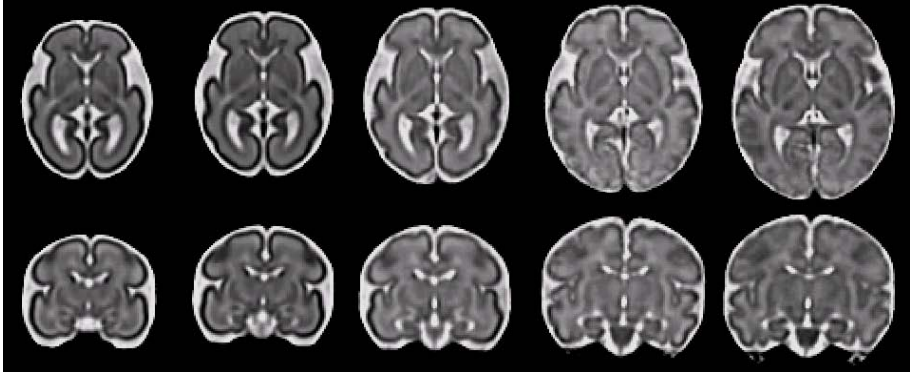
Five age points of the generated spatiotemporal fetal brain MRI atlas (at 27, 29, 31, 33, and 35 weeks GA). We used CC similarity metric to generate this atlas.
